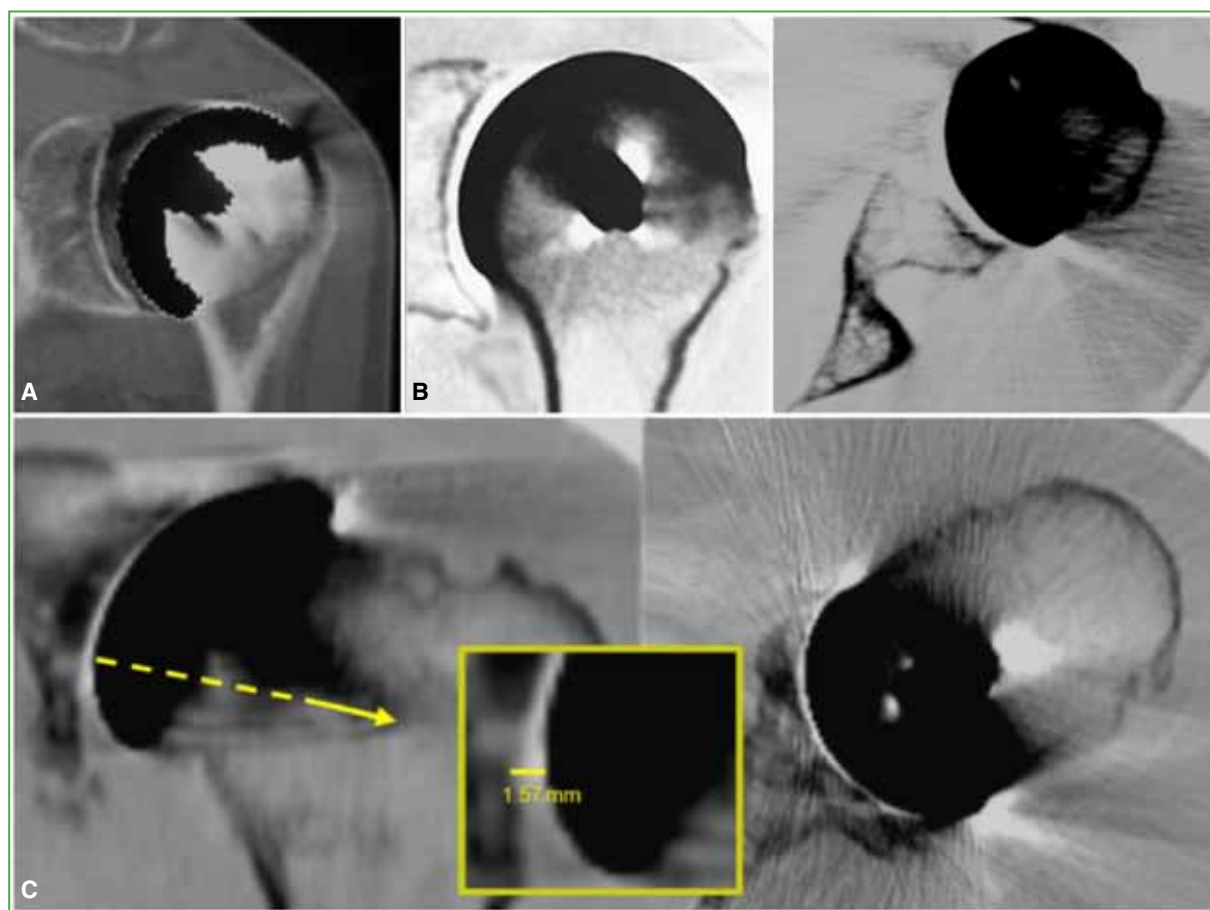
Postoperative radiographs of the patient in Figure 6. A. Immediate postoperative. B. Two years after surgery. C. Eight years after surgery.
